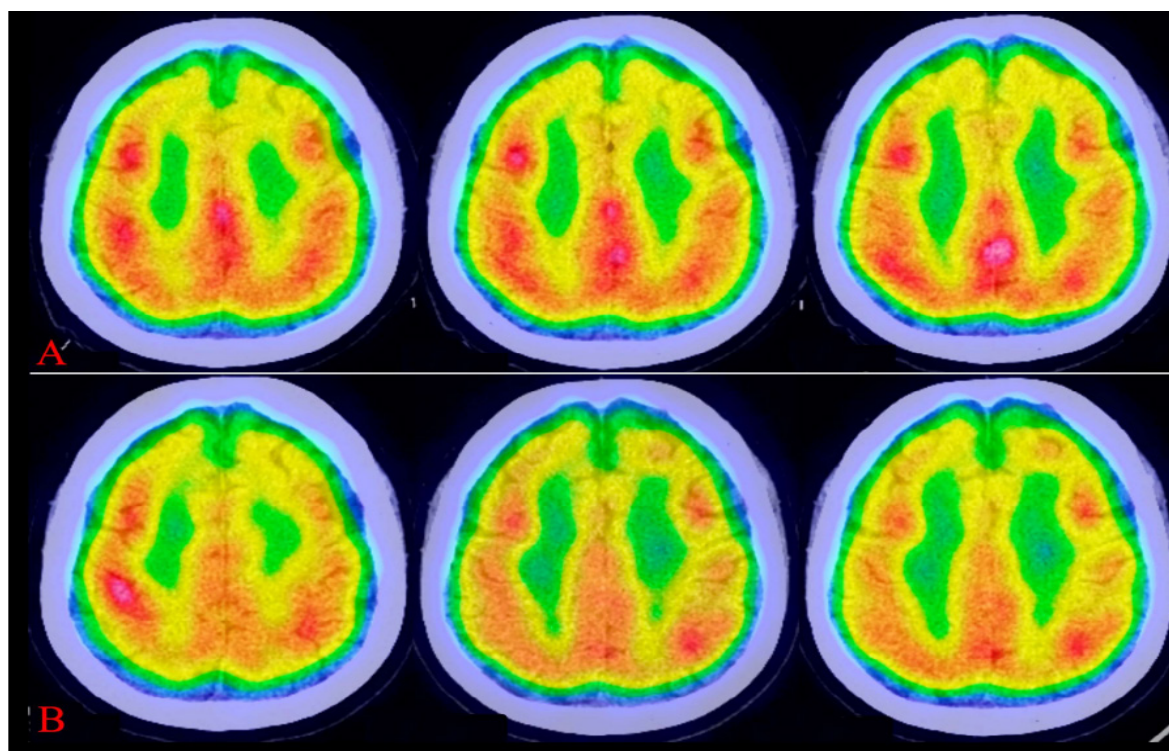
Comparison of brain SPECT/CT before and after duloxetine (A. Before; B. After)
